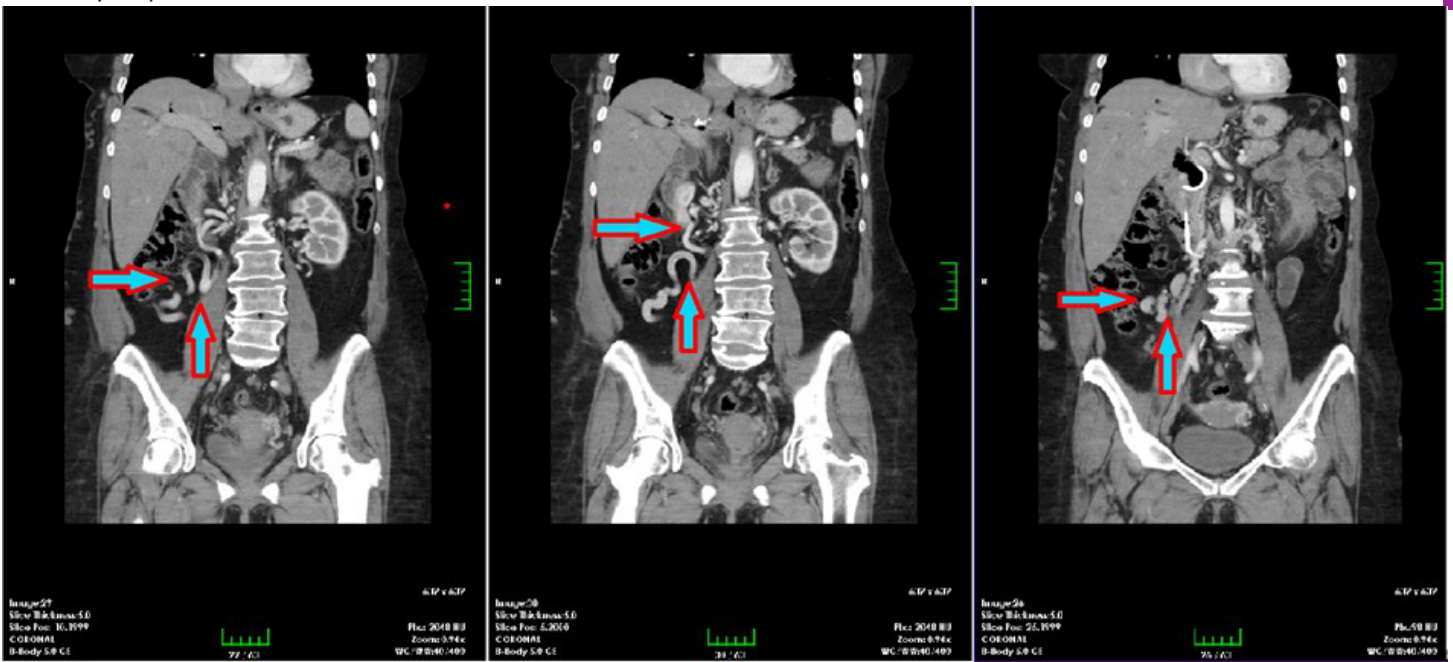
In I.V. contrast-enhanced CT sections taken in the axial plane; Venous vascular structures with ectatic dilatation increasing calibration to provide venous system drainage secondary to infra-renal IVC agenesis/atresia and diffusely tortuous varicose appearance at the levels of SMV and IMV roots are shown with arrows. The superior and inferior mesenteric veins drain into the vena porta via collaterals, then into the hepatic veins and then into the IVC.
